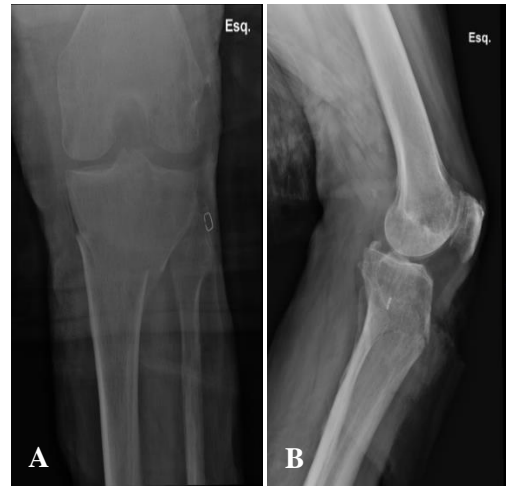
(A) AP radiograph showing 15 mm fracture displacement (B) Lateral radiograph showing a fracture without displacement.
